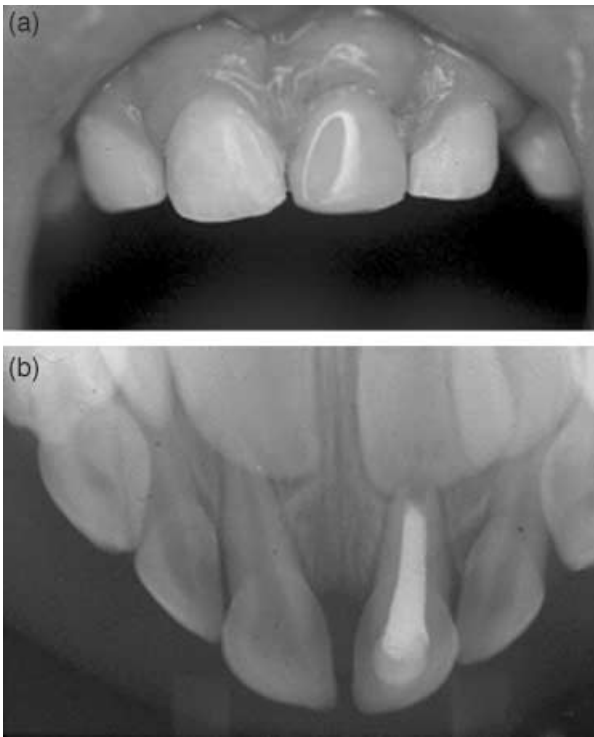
(a) Unacceptable aesthetic result observed in an endodontically treated incisor. (b) Radiographic appearance of a root-treated incisor.
